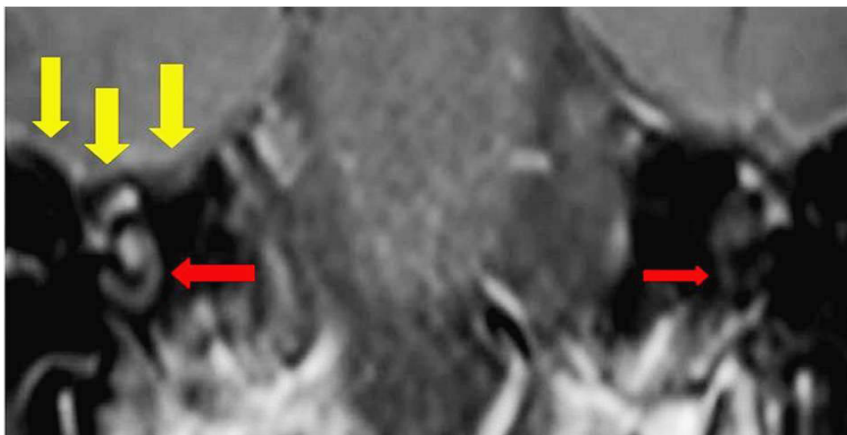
MRI with coronal view in T1 post-contrast sequence showing increased contrast enhancement of the right side cochlea (thick red arrow) and the left side cochlea (thin red arrow) showing normal enhancement. Meninges at the base of the temporal lobe at the right side showing linear enhancement (yellow arrows).
